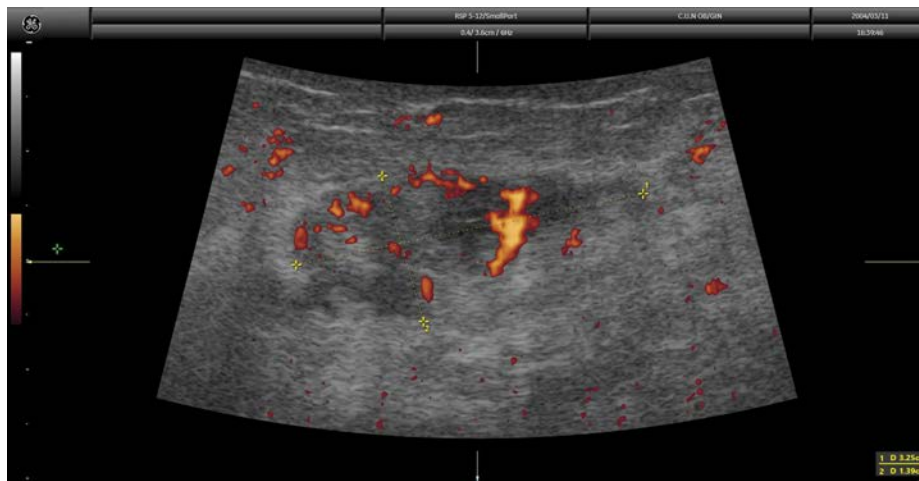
The same case as in Figure 11.1. Power Doppler allows the assessment of tumor vascularization.
